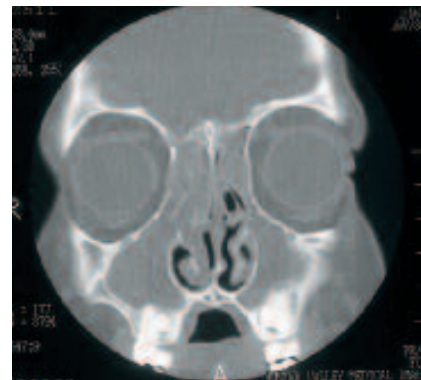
Computed tomography scan showing ethmoid and maxillary sinus involvement.
